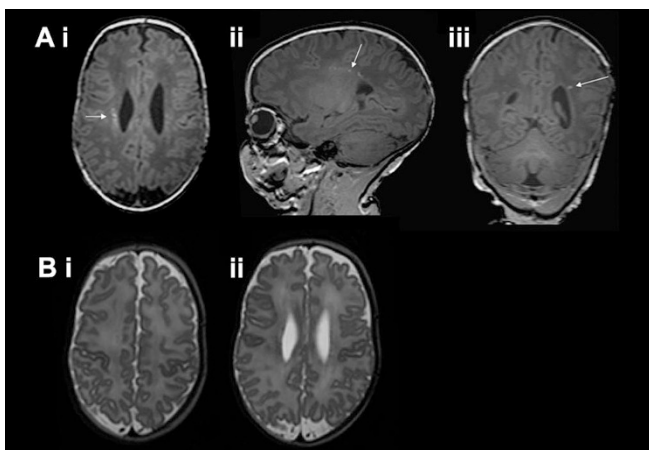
Images of the same infant as Figure 1 scanned at 42 wk PMA. (A) T1-weighted images in the i) axial, ii) sagittal, and iii) coronal planes and (B) T2-weighted images in the axial plane. The lesions are less numerous at 42 wk PMA on T1-weighted imaging (arrows) and cannot be clearly identified on T2-weighted imaging.
